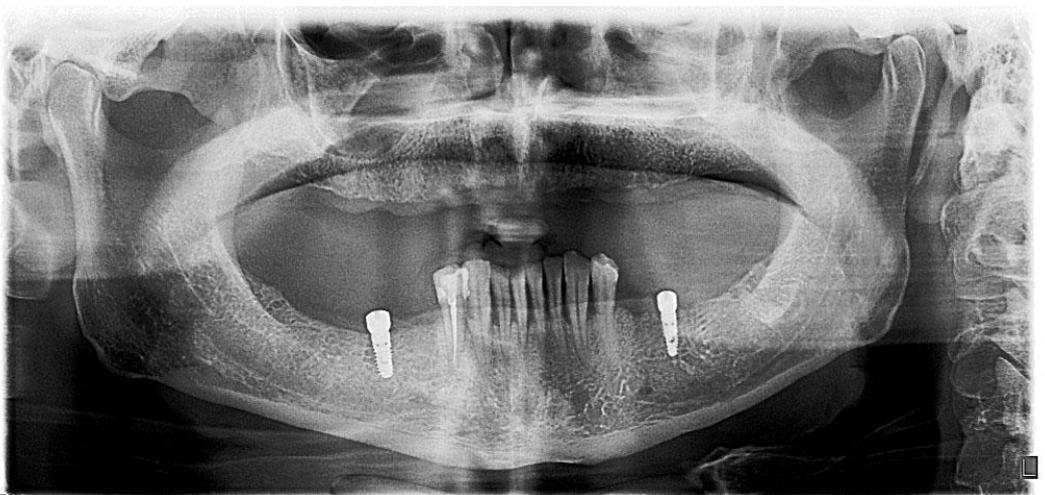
Digital panoramic x-ray to verify position and orientation of fixtures on both sides.
